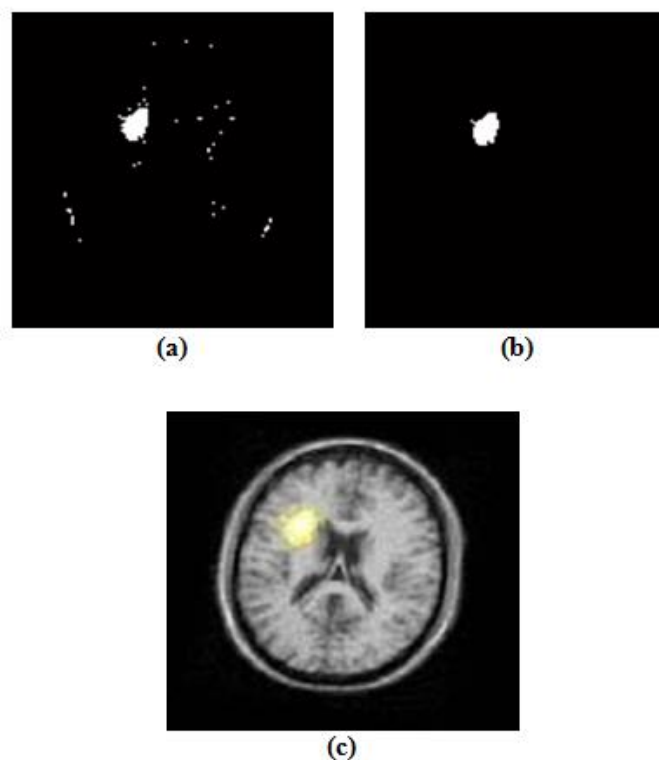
(a) Dilated image (b) Eroded image and (c) Tumor regionmarked brain MRI image
